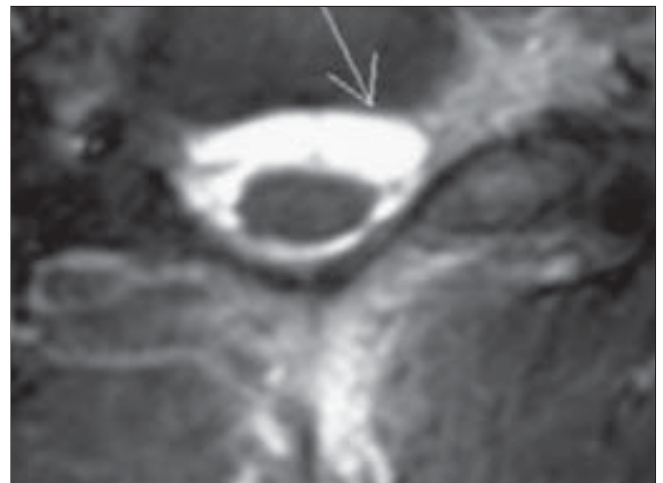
The MRI is more difficult to interpret
